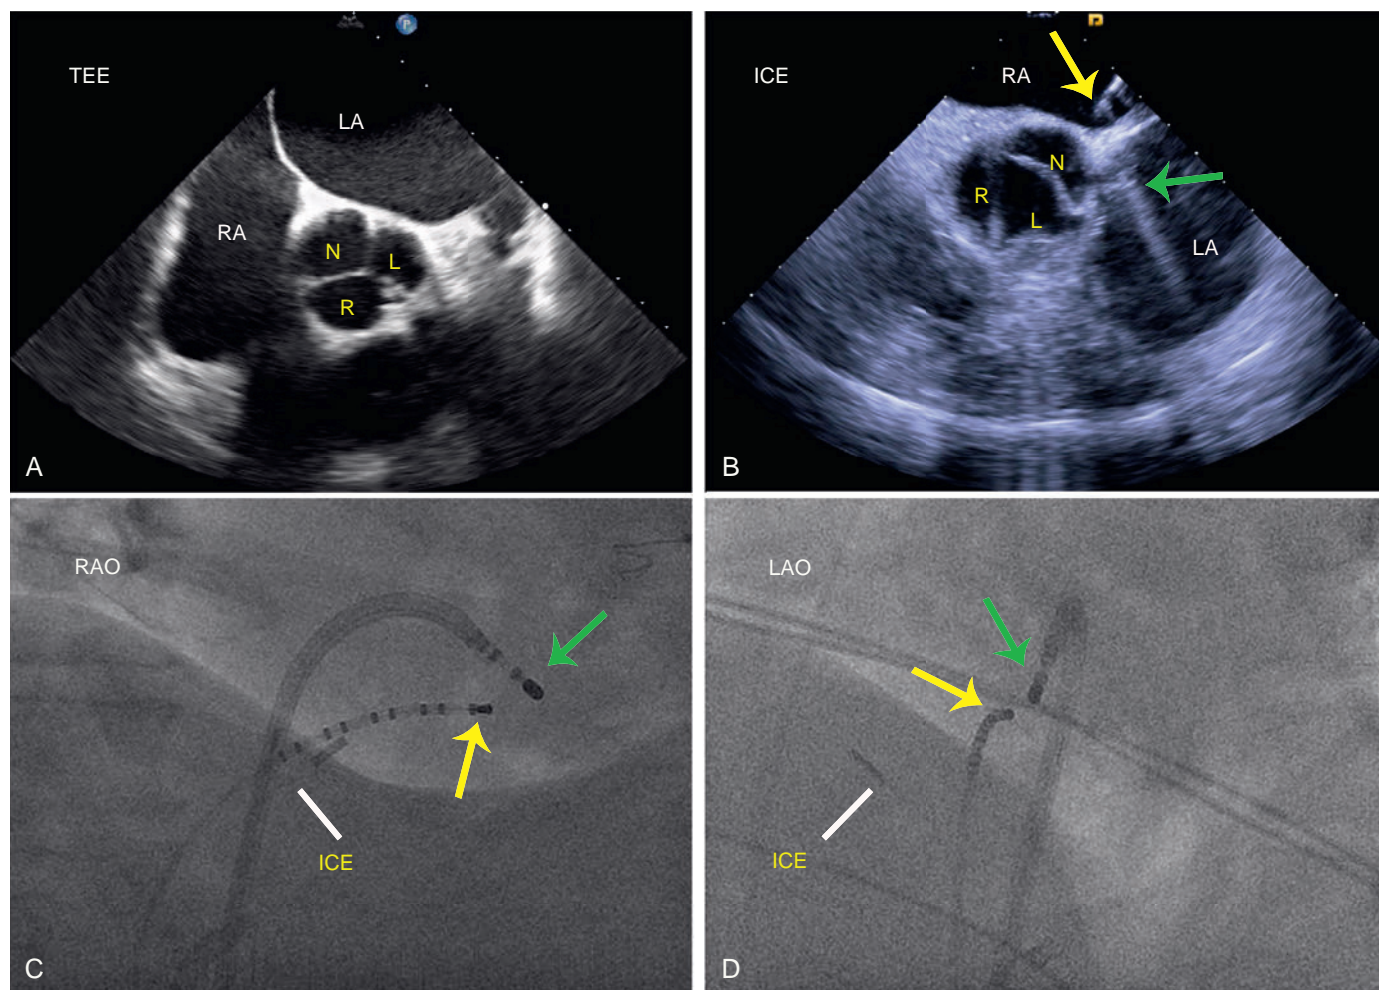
Anatomical Relationship of the Anterior Right Atrial (RA) Septum and Para-Hisian Regions. (A) Transesophageal echocardiography (TEE) showing the interatrial septum in relation to the aortic root and noncoronary aortic sinus of Valsalva (N). (B) Intracardiac echocardiography (ICE) showing mapping catheter positioned in the anterior RA septum (yellow arrow) in the His bundle region, and a second catheter positioned in the immediate left aspect of the septum (green arrow). Notice the close relationship of the noncoronary cusp sinus of Valsalva (N). (C and D) Right (RAO) and left (LAO) anterior oblique fluoroscopy views of mapping catheters positioned at the para-Hisian region (yellow arrows) and anteroseptal part of the left atrium (green arrows). L, Left sinus of Valsalva; R, right sinus of Valsalva.
